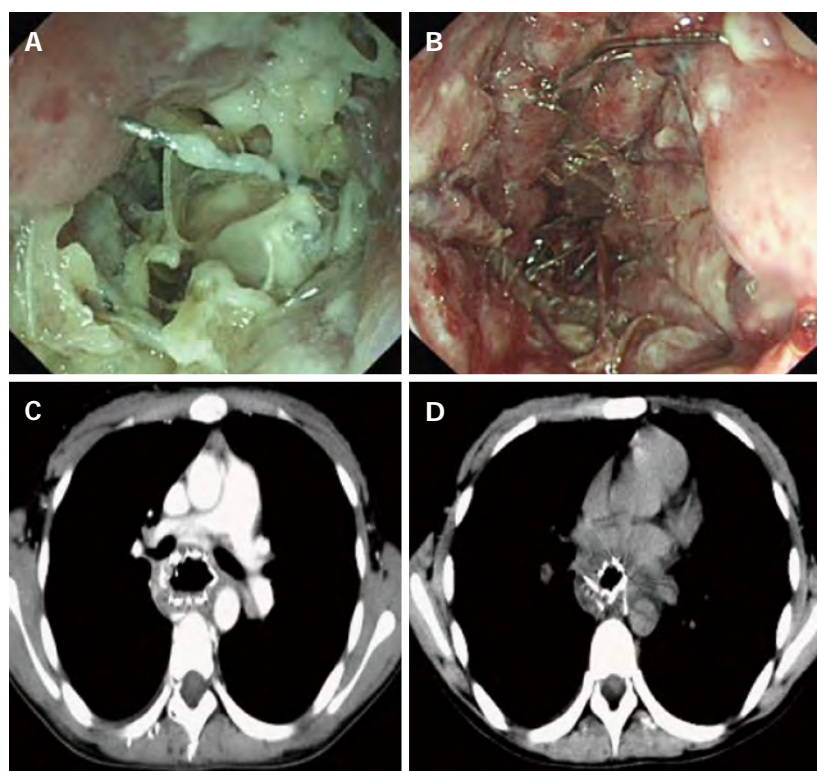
Disordered stent structure as a result of failure of repeated attempts at gastroscopic removal of the stent. A-D: Enhanced chest computed tomography scan performed showed the stent was situated in the middle section of the esophagus after esophageal stent placement, the wall of the middle and inferior segments of the esophagus thickened noticeably, part of the stent was embedded into the esophageal wall, borders between the stent and surrounding fat were blurred, and the upper end of the stent pressed against the trachea carina.
